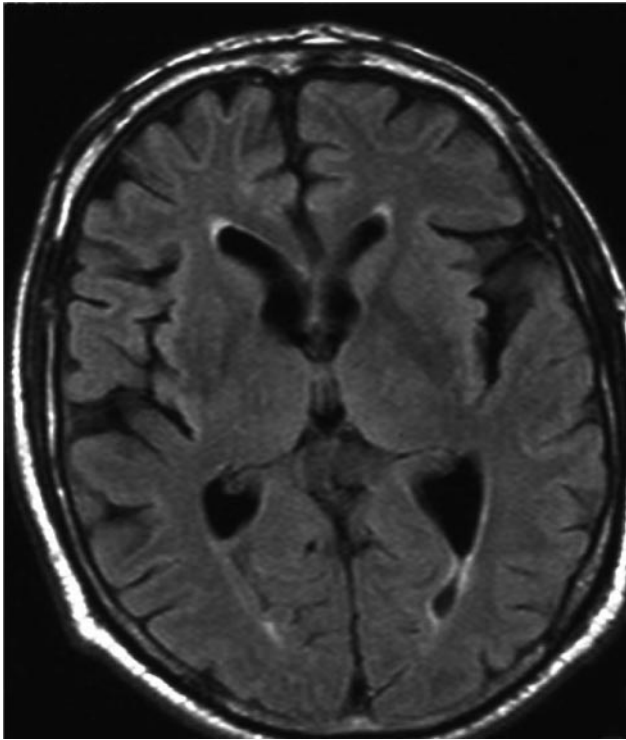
Axial flair MRI shows no lesions in both thalami.
